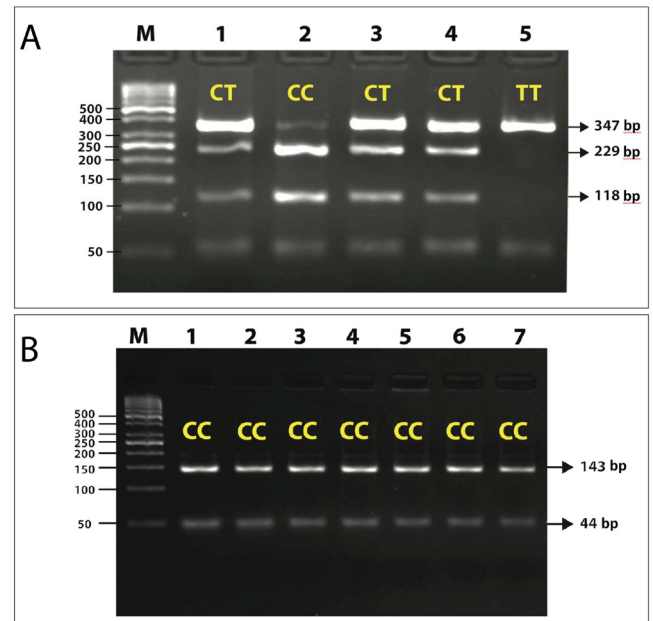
Gel electrophoresis image of enzyme digestion of PCR amplicons. (A) HphI enzyme digestion of the SNP C1772T (rs11549465) PCR amplicon (347 bp) produced 347 bp, 229 bp, and 118 bp fragments for the heterozygous genotype (CT), 229 bp and 118 bp fragments for the homozygous C allele (CC), and a single 347 bp fragment for the homozygous T allele (TT). (B) BglII enzyme digestion of the SNP C111A (rs779897997) PCR amplicon (187 bp) generated 143 bp and 44 bp fragments for the homozygous C allele (CC), no heterozygous (CA) or homozygous A allele (AA) genotypes observed. M: Marker; 1-5: Case numbers (Panel A); 1-7: Case numbers (Panel B); bp: Base pair.
